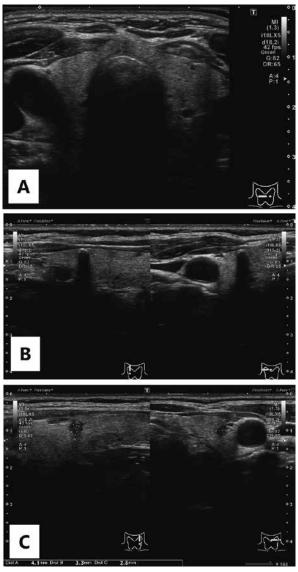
No mass suspected of being thyroid cancer was found on the thyroid ultrasound. (A) Left lobe: Multiple hypoechoic masses suspicious for adenomatous nodules, max 7 mm in diameter. (B) Right lobe: Hypoechoic masses suspicious for adenomatous nodules, 3 mm in diameter. Calcified lesion with acoustic shadow, 3 mm in diameter. (C)
